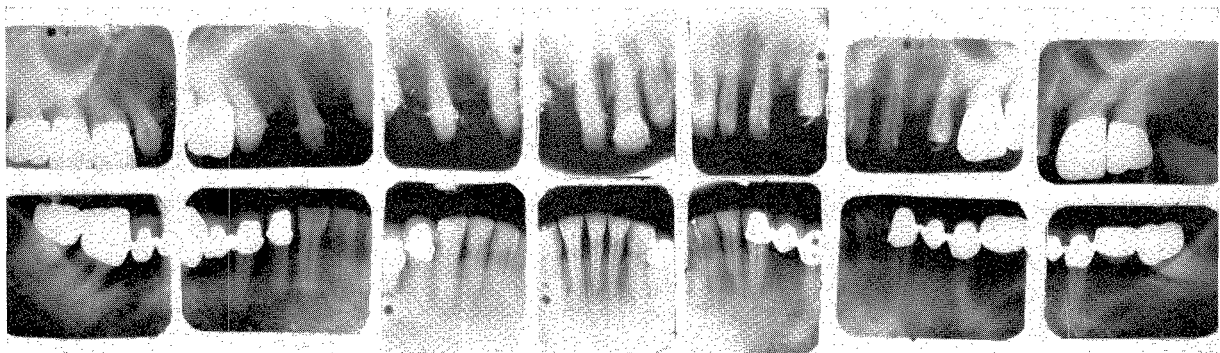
Roentgenograms taken at the start of treatment in 1954. The plastic temporary bridges which were in position do not show in the radiographs.
